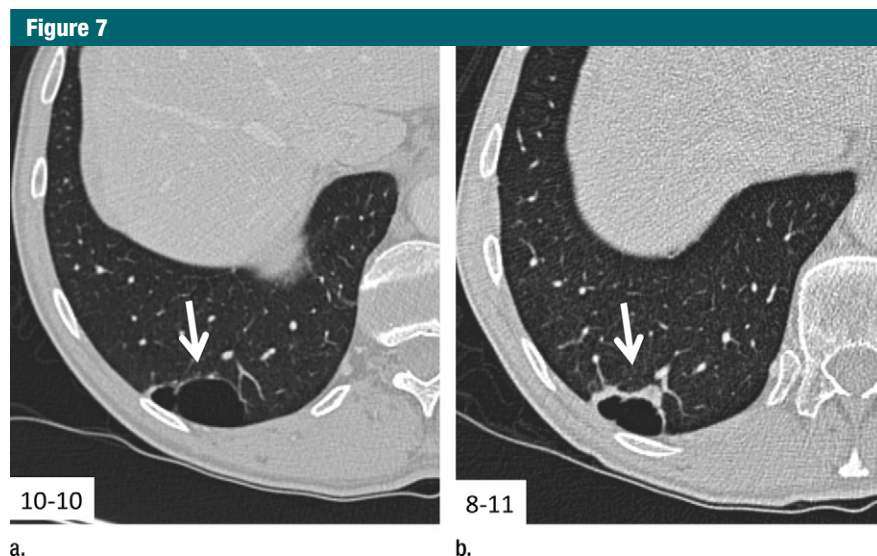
Transverse 1-mm CT sections obtained 10 months apart show a highly suspicious pattern of progressive thickening in the wall of a right lower lobe cyst (arrow). Resection revealed invasive adenocarcinoma.
